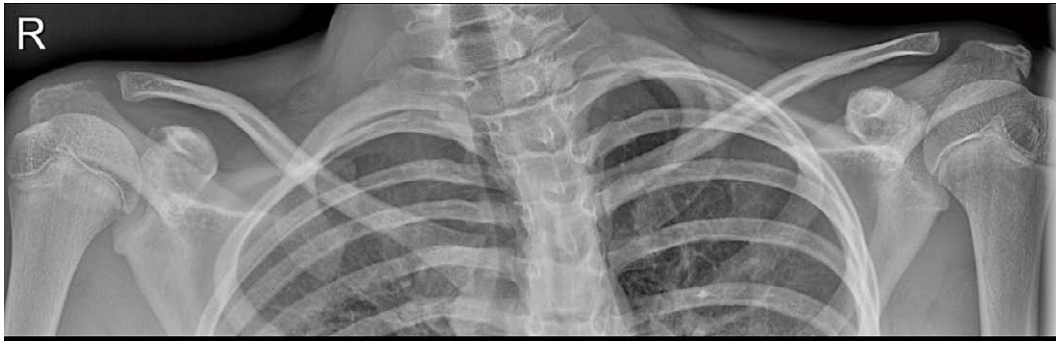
Radiographic examination reveals a sternoclavicular dislocation whereby it is difficult to determine the direction of dislocation.
